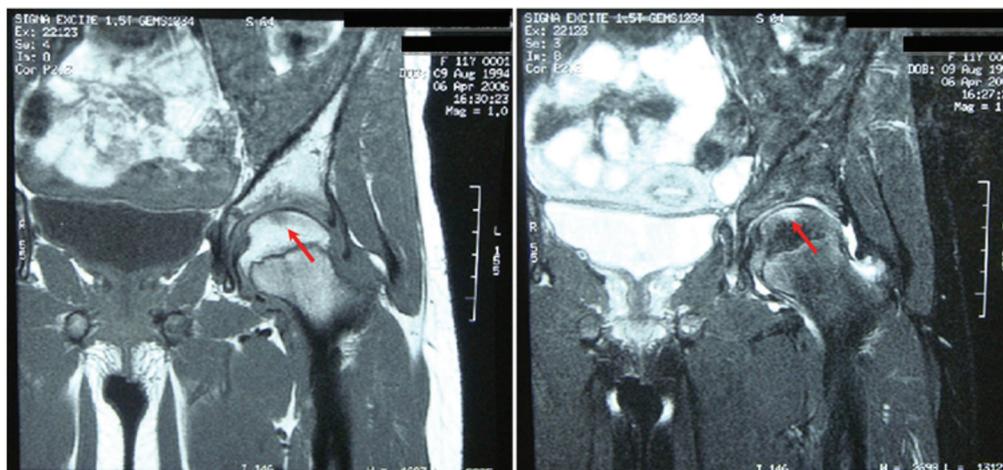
Initial magnetic resonance imaging of the left hip. Coronal plane, T1- and T2-weighted fast spin-echo sequence showing moderate joint effusion and a small area with hyposignal in T1 and hypersignal in T2 (arrow), compatible with subchondral edema.
